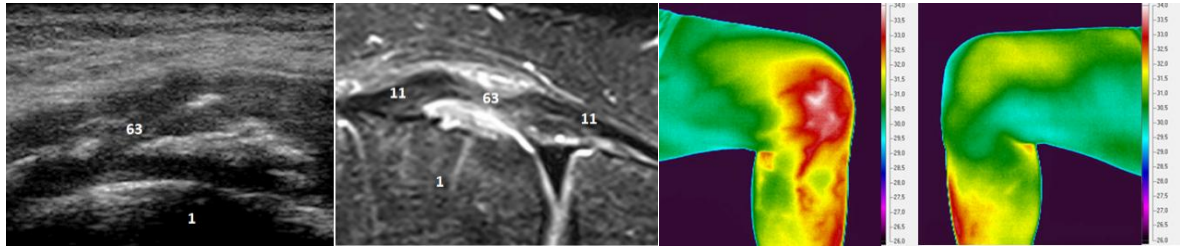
sono, Fig.6b.MRI, Fig.6c.TMV. Sono, MRI: periosteal abruption of the LCM attachment to the medial femoral condyle. TMV: focal finding of increased thermal activity in medial part of left knee. 1. condylus medialis femoris, 11. ligamentum collaterale mediale, 63. rupture.
